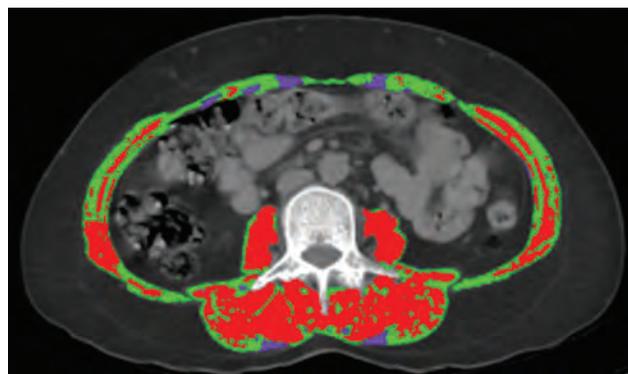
Muscle quality map at L3 derived from abdominal CT using region growing mode. The axial CT images at L3 were segmented into NAMA (red), LAMA (green), and IMAT (purple).
